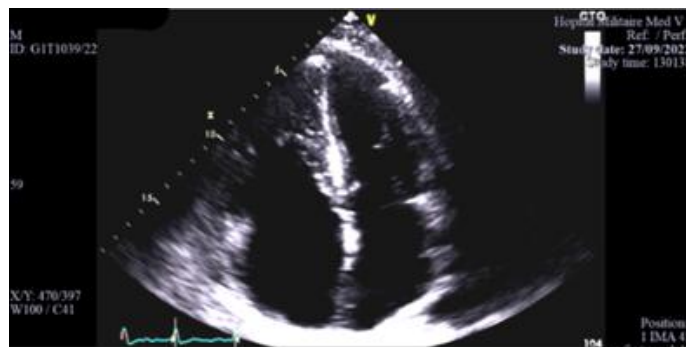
2D echocardiographic image in apical four-chamber view showing dilation of the right cavities with inversion of the RV/LV ratio, which is > 1.
